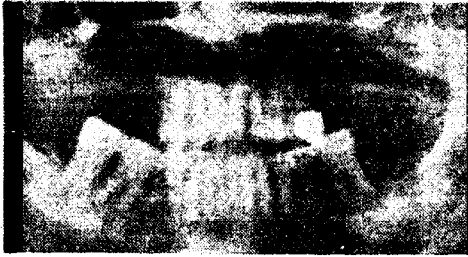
Preop orthopantomograph.
